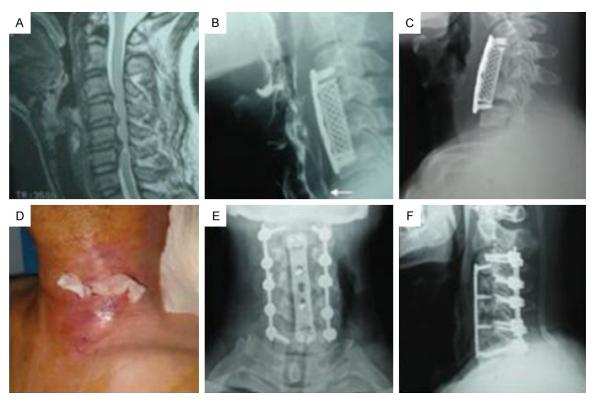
EF-infection-resulted cervical internal fixation loosening, which thus led to the cervical kyphosis, combined anteroposterior cervical orthopedic surgery. A. Cervical MRI: cervical 3/4, 4/5 and 5/6 disc herniation; B. Lateral cervical X-ray image: the barium meal leaked from EF wound; C. The EF would was infected, thus the internal fixation was loosened, and the cervical kyphosis was induced; D. Situations of wound infection; E and F. The patient was firstly performed anterior cervical fixation to remove and debride the infected parts, as well as posterior cervical kyphosis and anterior cervical autoallergic iliac bone graft plus Titanium plate internal fixation. The wound was then placed washing tube and suction drainage tube. The patient was then placed the nasogastric tube for the nasogastric feeding.
